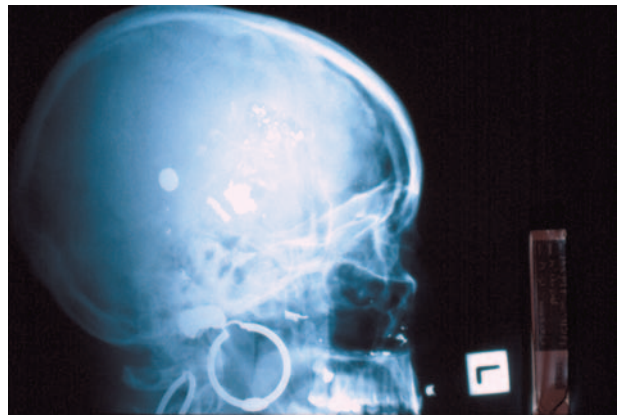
Multiple gun shots to the head. .38 Special. Homicide. The X-ray shows three large discreet fragments, some separated jacketing, and smaller lead particles.
